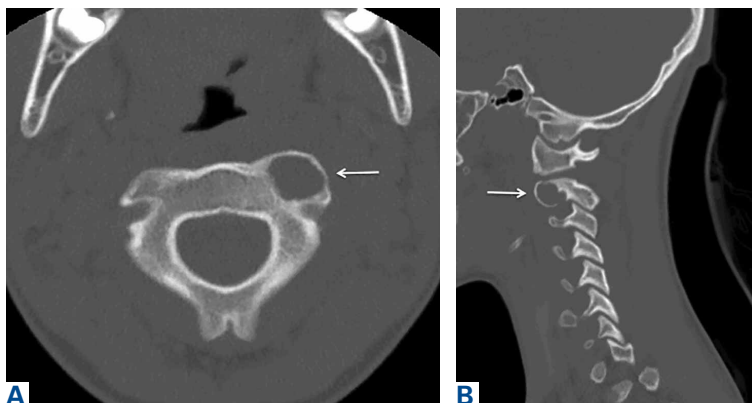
(A) Axial and (B) sagittal computed tomography shows discrete, expansile, radiolucent mass extending anteriorly from left C2 vertebral body.
